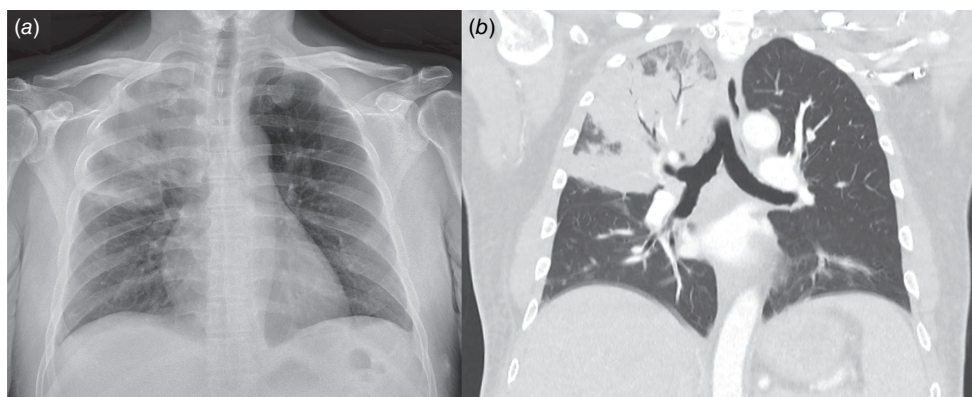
A chest X-ray (a) and computed tomography scan (b) demonstrating right upper lobe pneumonia in a patient with diabetes who presented with 7 days of fever and cough.
